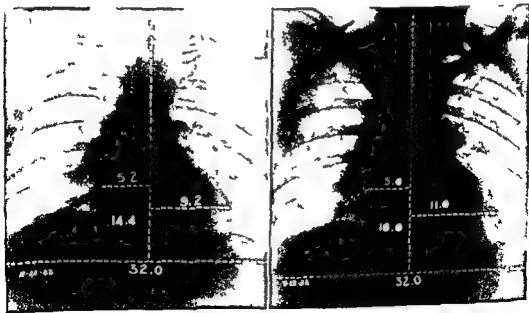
ADDISON'S DISEASE Heart size in 56 year old man with previous hypertension before and 7 months after treatment with desoxycorticosterone pellets (*Left*) Weight 164 lbs BP 90/60 at time of first roentgenograms Note hypertensive shape of heart (*Right*) Weight 151 lbs BP 160/110
